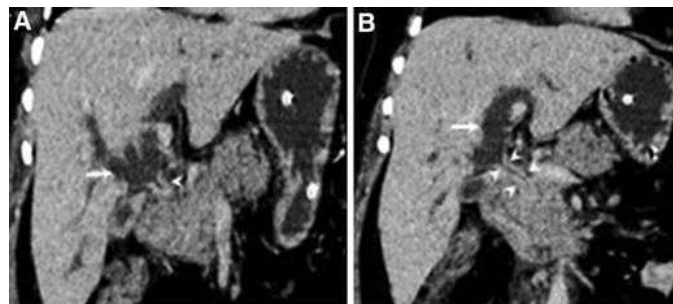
a and b contrast-enhanced coronal images of CT scan showing long segment enhancing wall thickening involving CHD and CBD (arrow head) with secondary upstream dilatation of intrahepatic bile ducts (arrow)
